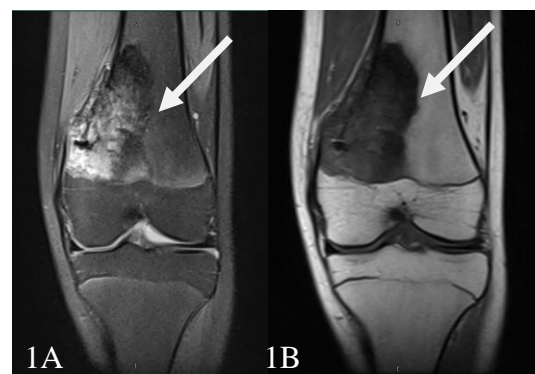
Preop and pre-ECI MRI of the case. 1.A. proton T2 sequence. 1.B. T1 sequence. Reported possible tumoral structure is indicated by the arrow.
